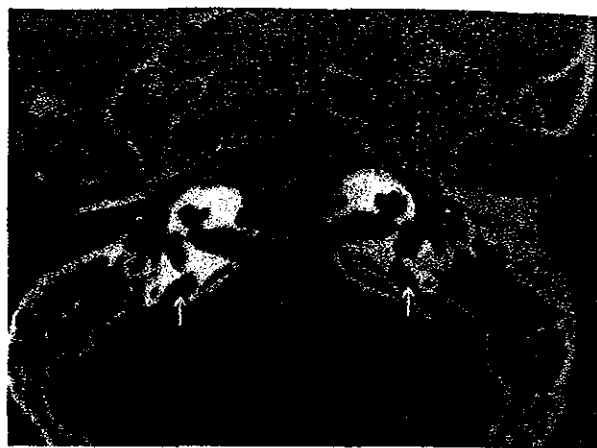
Axial CT showing bilateral enlarged vestibular aqueducts (white arrows).
